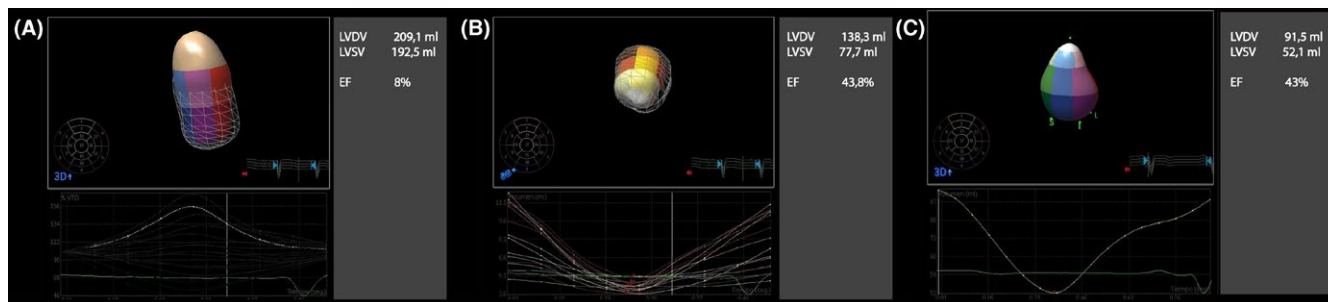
Preoperative measurements (A), “virtual aneurysmectomy” predictions (B), and 6-month postoperative measurements (C) of left ventricular diastolic and systolic volumes (VTD and VTS) using three-dimensional transthoracic echocardiogram (3DTTE)
